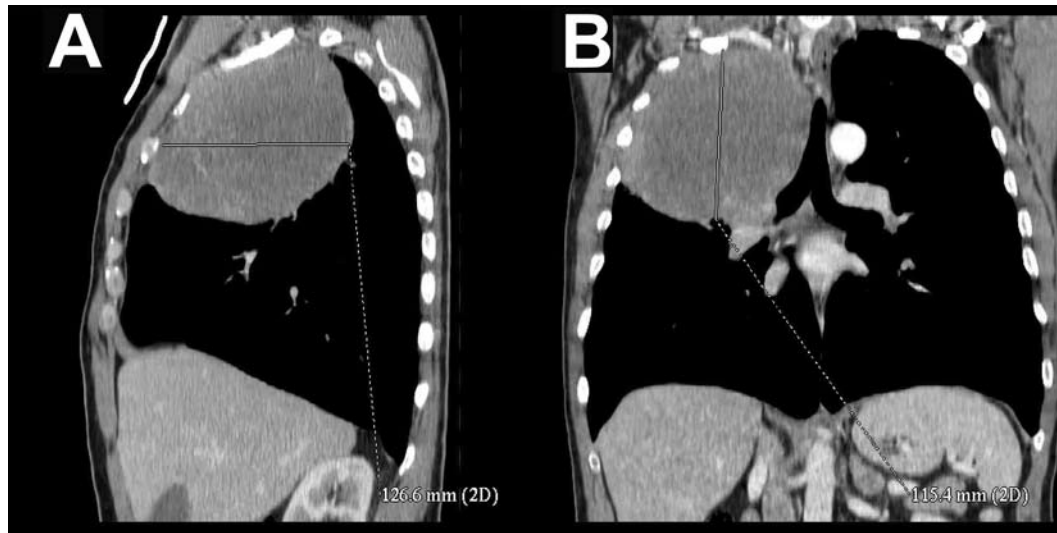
Tumor of the upper lobe of the right lung visible on CT-scan in lateral (A) and antero-posterior projection (B).
